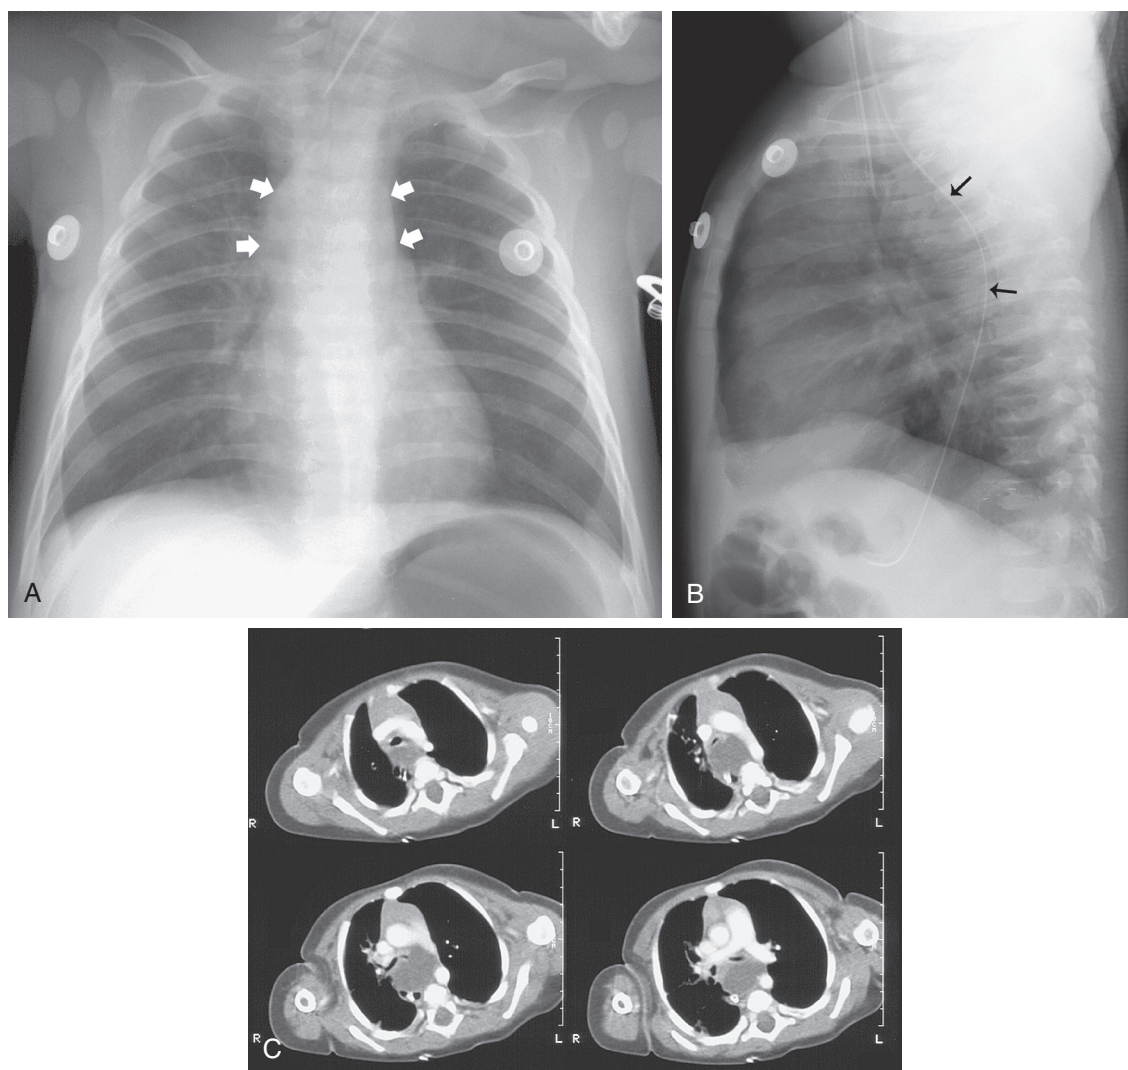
■ Bronchogenic cyst in a 4-month-old boy with cough. Anteroposterior (A) and lateral (B) chest radiographs show a central mediastinal mass (*white arrows*) displacing the esophagus (outlined by nasogastric tube, *black arrows*) posteriorly. C, Four contiguous axial computed tomography images of the chest show a retrotracheal and subcarinal mass with low-density contents. Excision of the mass and pathologic examination showed bronchogenic cyst. (Courtesy Simon C. Kao, MD, Iowa City, IA.)
